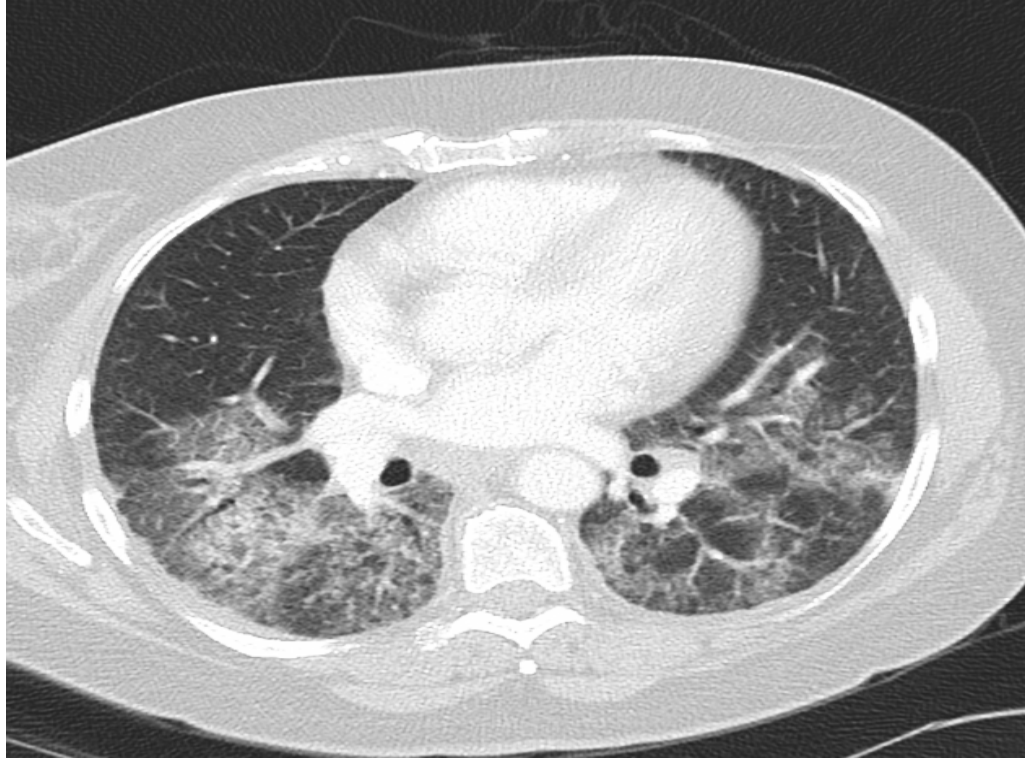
lung CT scan in FES
